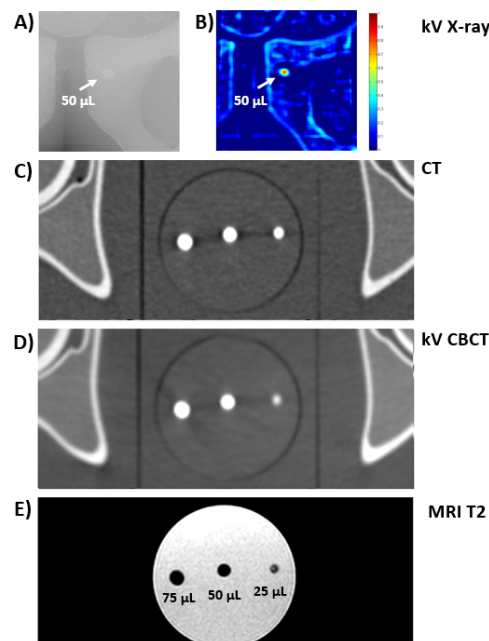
overview of the visibility of intermediate size (25-75  $\mu$ L) liquid fiducial markers for the different imaging modalities employed in this study. A: shows a 2D kV X-ray image (110 kVp, 10 mAs) and B: the corresponding NCC plot for a 50  $\mu$ L marker. C to E: show transversal slices of CT (120 kVp, AEC), CBCT (125 kVp, 1080 mAs) and MRI (1.5 T, T2-weighted) for the 75  $\mu$ L, 50  $\mu$ L and 25  $\mu$ L markers respectively. The markers were clearly visible on the volumetric images and caused minimal image artefacts.
